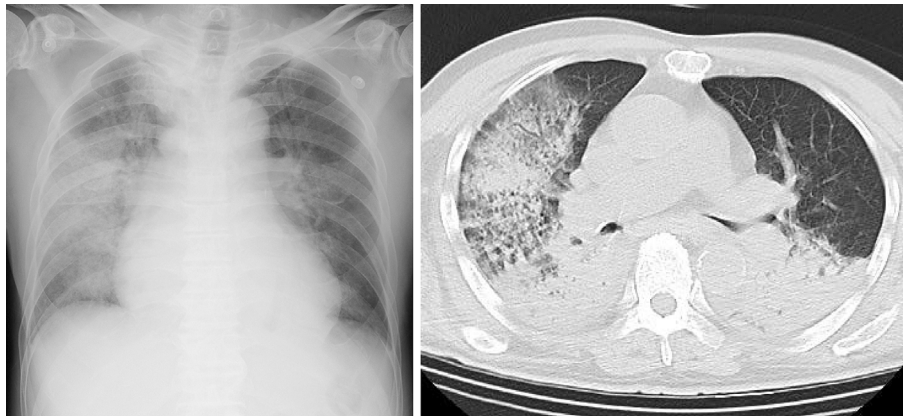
Chest radiograph and CT scan on admission reveal diffuse consolidation in both lungs (right>left).
